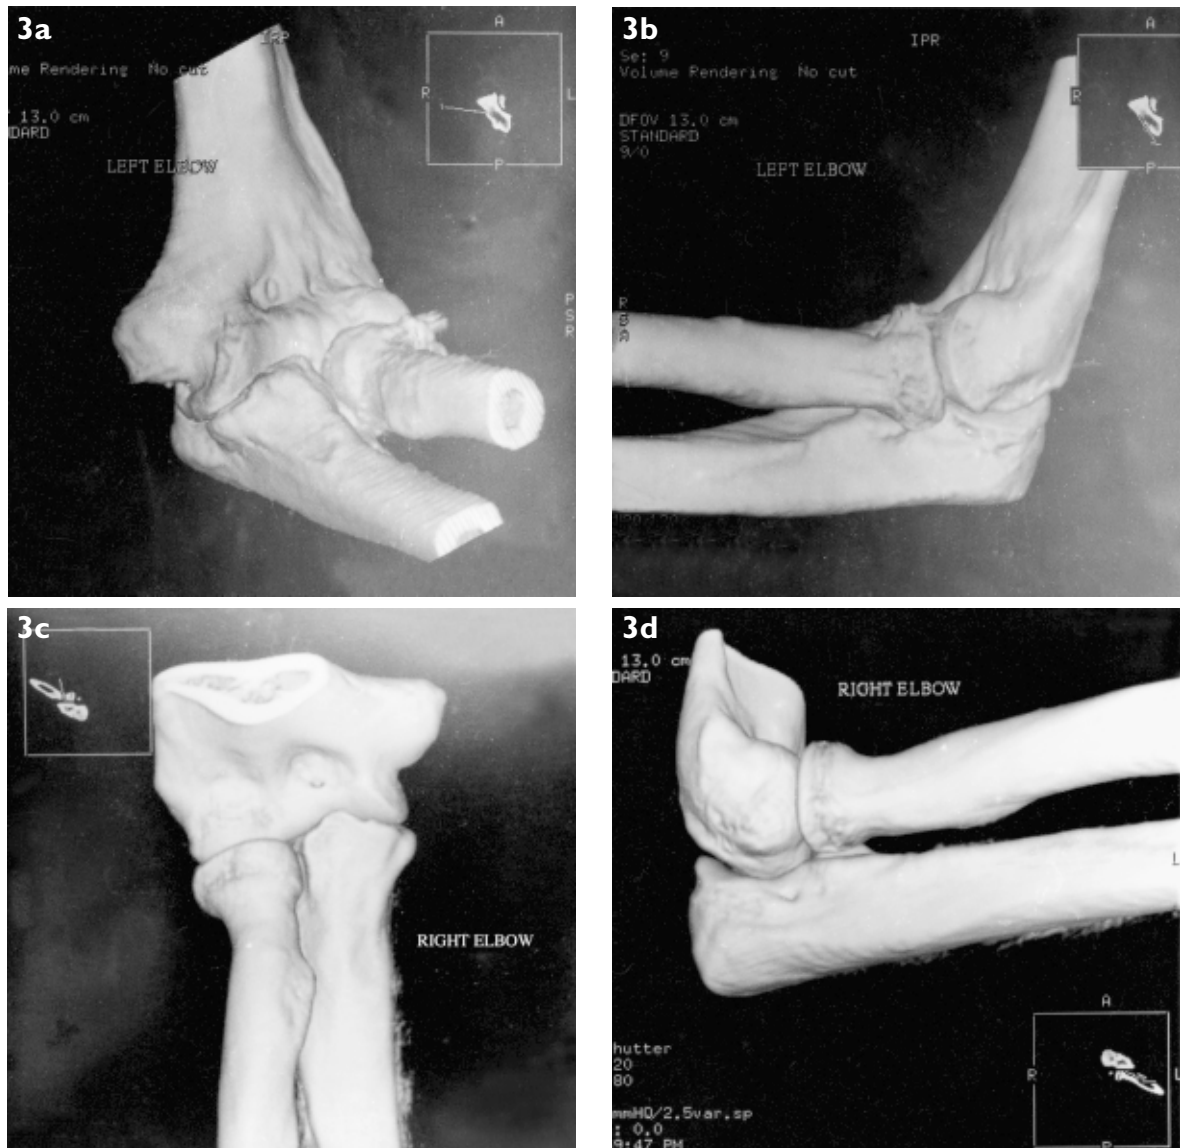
Case 7. CT images with 3D reconstruction of both elbows done for comparison at 40 months after open reduction of the left elbow. (a, b) The left elbow, the injured side, is not subluxed. The ulno-humeral and radio-capitellum articulations appear congruent. The collateral ligaments were not reconstructed. (c, d) The right elbow is the uninjured side. The appearances of both the elbows are comparable.
